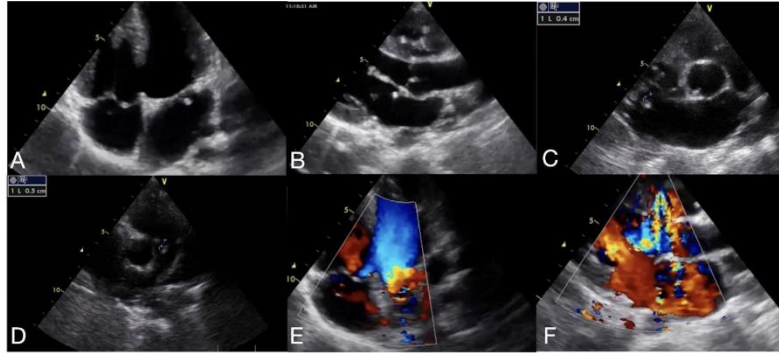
Panel A: Apical 4-chamber view showing images suggestive of vegetations on the mitral and tricuspid valves, as well as a perimembranous ventricular septal defect with a maximum diameter of 20 mm. Panel B: Parasternal long-axis view showing a mobile vegetation on the anterior leaflet of the mitral valve and the non-coronary cusp of the aortic valve. Panels C and D: Parasternal short-axis view at the level of the great vessels, revealing images suggestive of a mobile vegetation attached to the tricuspid and pulmonary valves. Panels E and F: Apical 4-chamber view and Parasternal short-axis view showing perimembranous ventricular septal defect with right to left flow by color doppler.
